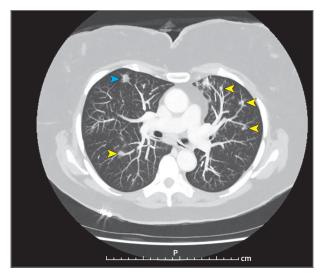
Postcontrast computed tomography image of the chest and lung window (8-mm maximum intensity projection slice) demonstrates multiple small bilateral lung nodules involving multiple lobes (yellow arrowheads). A larger, more focal nodule (blue arrowhead) is seen anteriorly within the right upper lobe.
